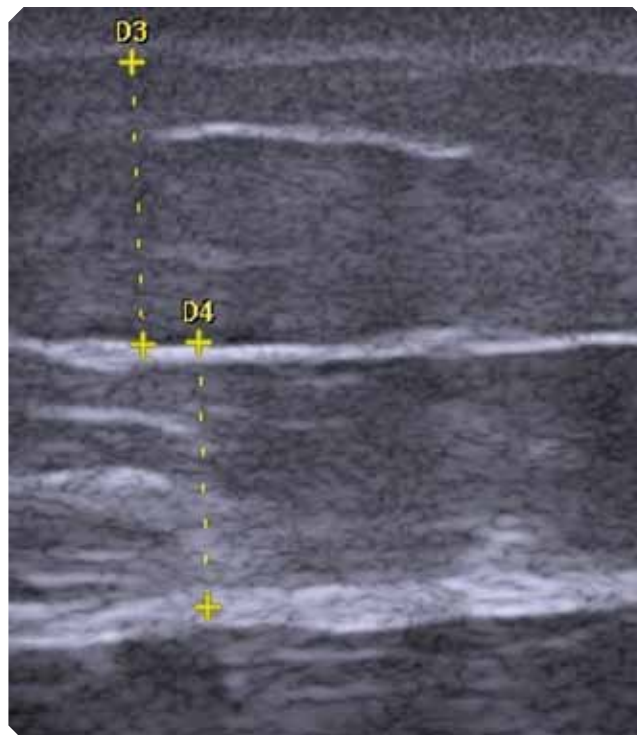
High-frequency high-resolution ultrasound of right thigh after 10th HERST treatment, corresponding to cellulite degree 0-I.
